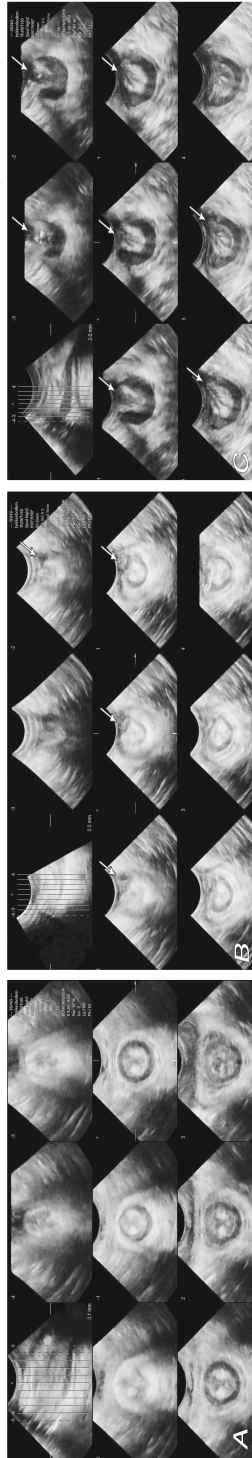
Example of intact anal sphincter (A), residual defect of external anal sphincter (B) and complete residual defect of anal sphincter (internal and external) (C) during maximal pelvic floor muscle contraction with 3D/4D transperineal ultrasound.
